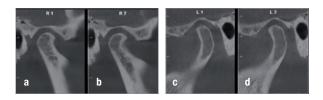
Post-treatment CBCT images of both temporomandibular joints (sagittal views). (a & b) Right. (c & d) Left.
